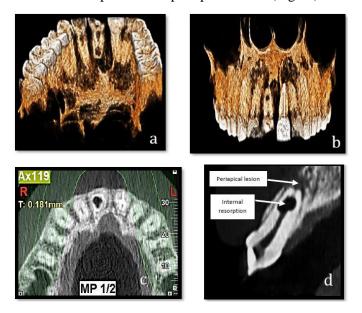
CBCT imaging showing a well-defined resorptive lesioninapical third of maxillary right central incisor tooth. Evidence of a layer of dentine present surrounding the resorbed area confirms there is no root perforation as such.
